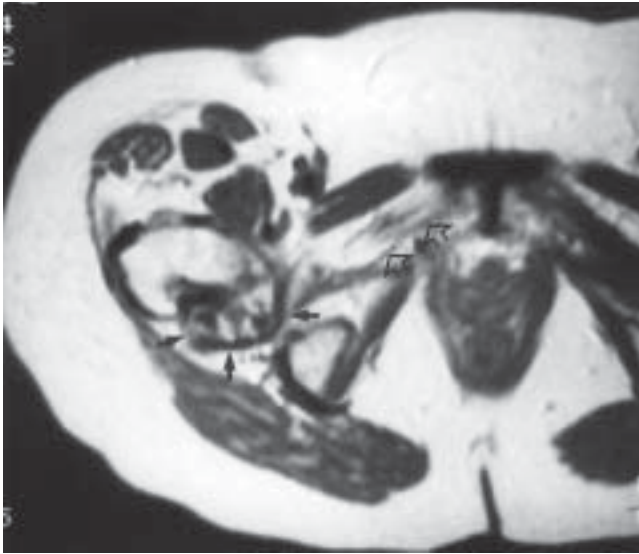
56-year-old woman with chronic right hip pain. T1-weighted axial MR image of the pelvis shows atrophy of the obturator externus muscle (open arrows) due to compression by a soft tissue osteoma (arrows).
